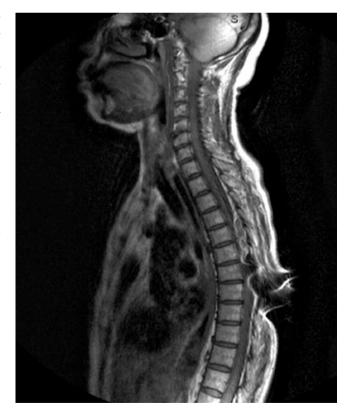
MRI of lumbar spine with artifact due to epidural catheter. Personal library
